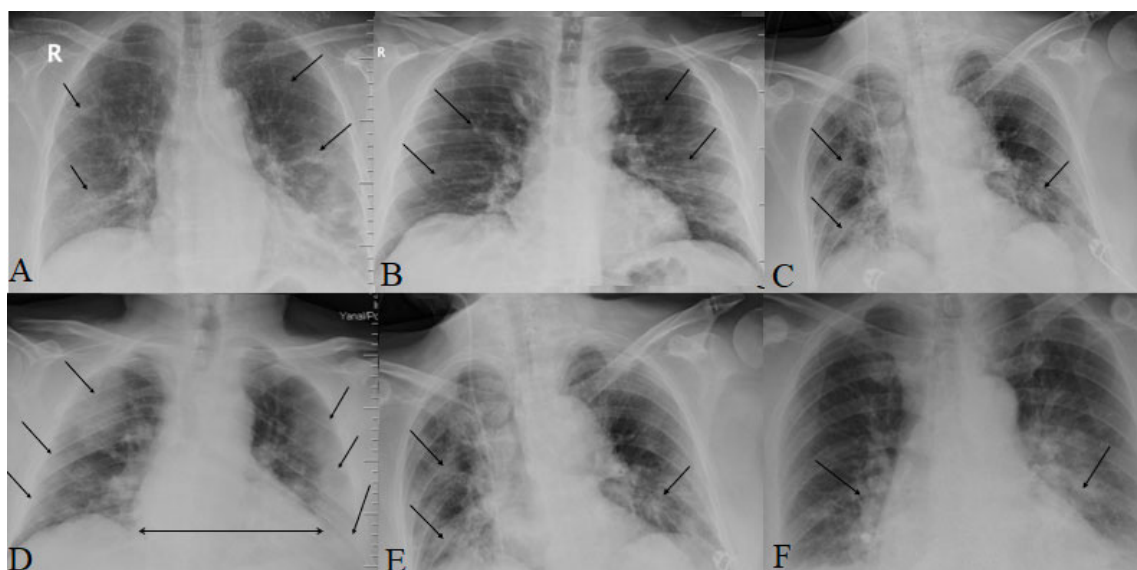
Chest X-Ray findings of Covid-19 pneumonia. A, Bilateral and peripheral ground-glass opacities. B, Reticular-nodular opacities. C, Patchy consolidation. D, Peripheral consolidation, pleural effusion and cardiomegaly. E, Vascular congestion. F, Bilateral and central ground-glass opacities.
